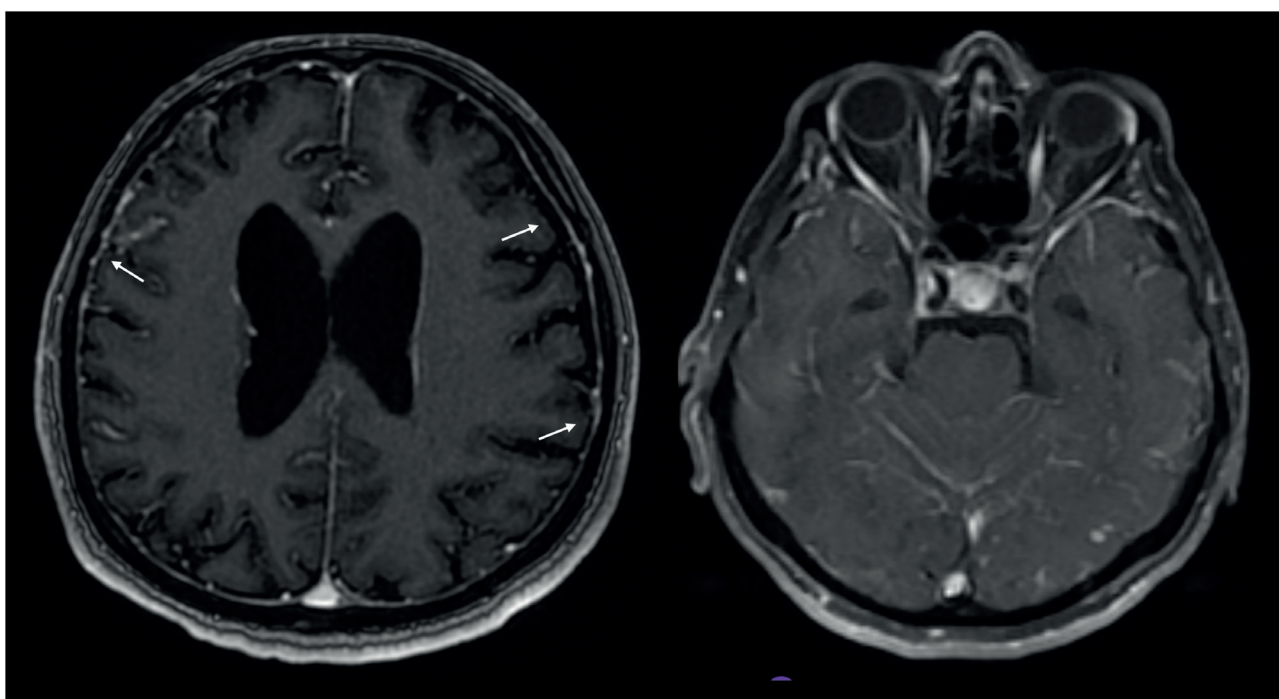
Case-3. Contrast-enhanced MRI of brain. Contrast-enhanced T1-weighted axial image. Showed leptomeningeal involvement (white arrow).
